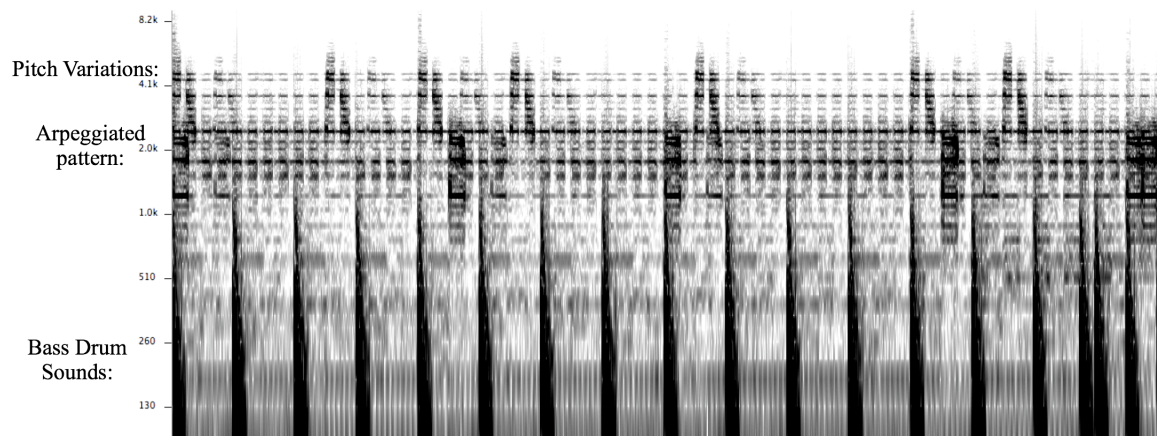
Sonogram of Mocean Worker’s *Waiting for Verdeaux*, 0:15–0:21 (sixteen beat-cycles).
